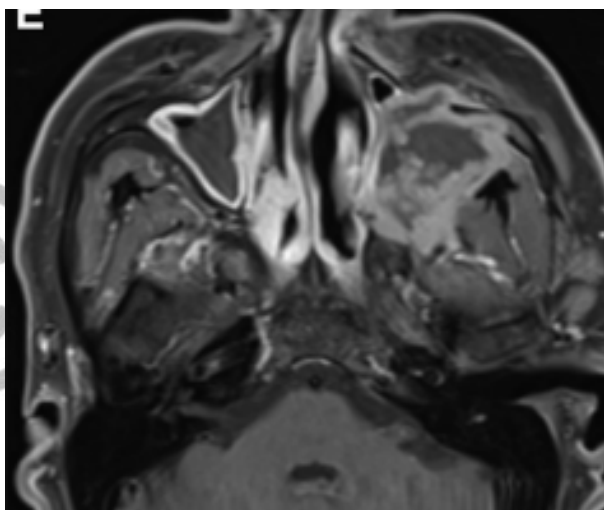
Chronic invasive fungal rhinosinusitis. MRI scan, T1 mode with contrast enhancement and suppression of adipose tissue. On the axial section, there is an increase in the peripheral areas of the formation with a less pronounced central area.
